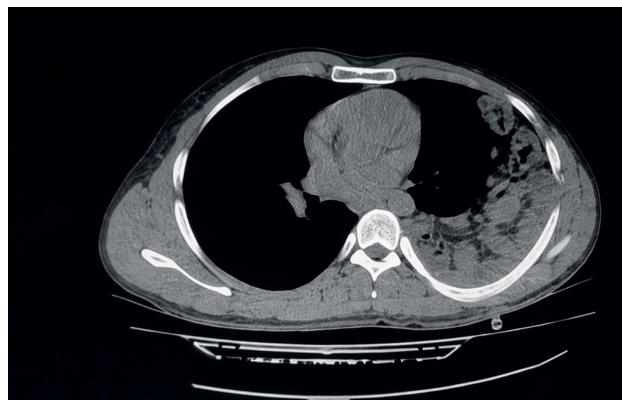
Preoperative computed tomography scan of case
